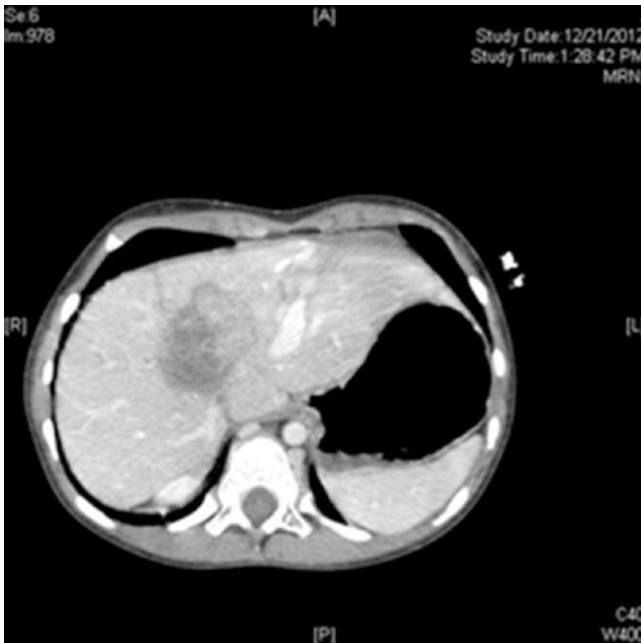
CT image of a hepatoblastoma in a 6-year-old child. This child had persistent PRETEXT III tumor after six cycles of chemotherapy. The tumor was closely approximated to the cava. She underwent primary living donor liver transplantation
